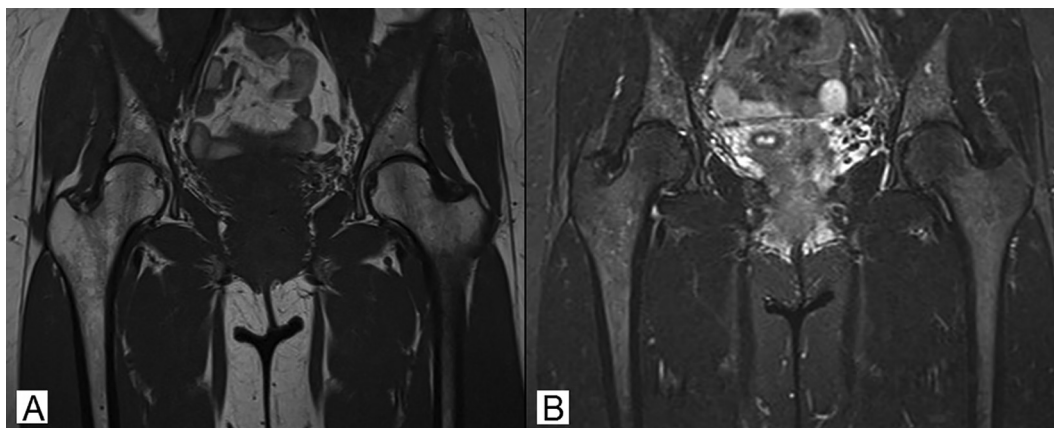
Magnetic resonance imaging (MRI) of pelvis, follow-up at four months. A. Coronal T1-weighted image; B. Short tau inversion recovery (STIR) image, complete regression of earlier changes.
